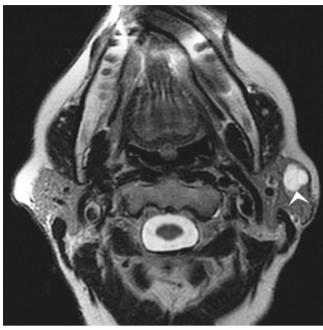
Pleomorphic adenoma of the partotid gland. T2-weighted MRI demonstrates a well circumscribed hyperintense mass (*arrow*) with a bosselated contour, within the left parotid gland, typical of a pleomorphic adenoma
